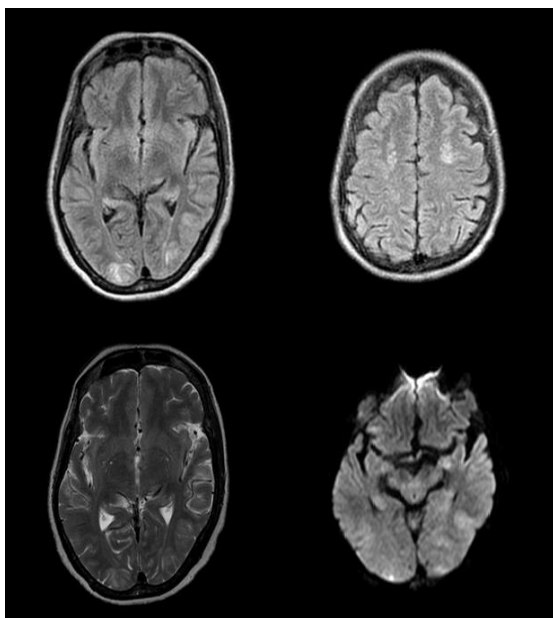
A 65-year-old female, came with the complain of drowsiness following sudden onset increase in blood pressure. MRI finding suggest hyperintense signal intensity in cortical and subcortical region of bilateral front parietal lobe suggestive of vasogenic edema. It also shows foci of restricted diffusion on DW images in bilateral occipital lobe
